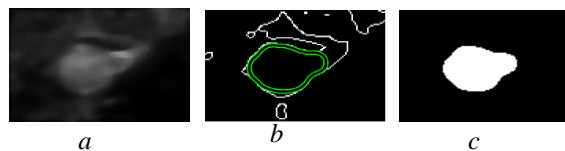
a* represents the ultrasound image of sample 17 after speckle noise reduction. The image in figure *b* shows employing active contour on the edge detection image (resultant image after using FEDM), while figure *c* depicts the binary object.
